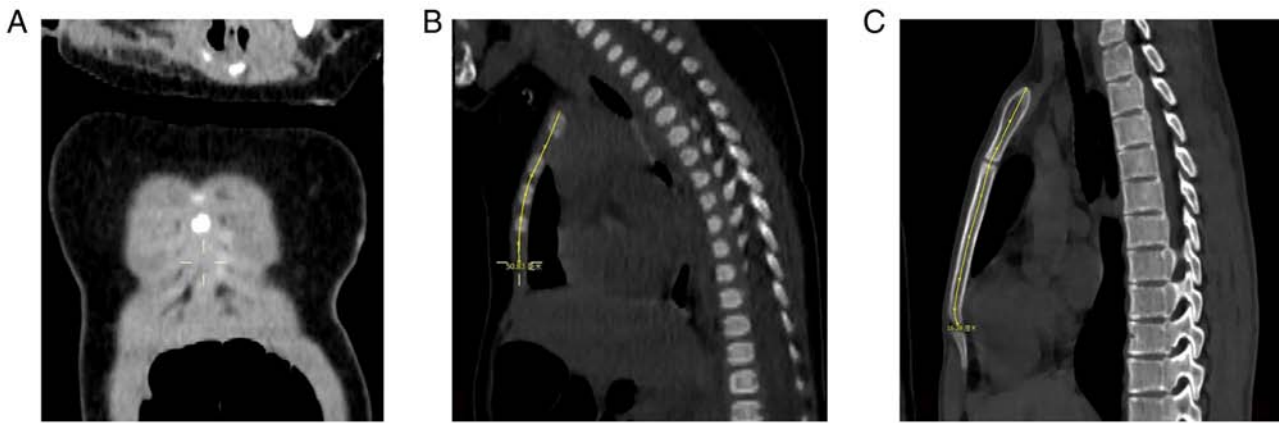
Definition of the length of the sternum. (A-C) Multiplanar reformatted MDCT images. (A) The junction of 6th/7th costal cartilage. (B) The TSDS before the ossification centers completely merged into a single ossification center. (C) the TSDS after the ossification centers have completely merged into a single ossification center, which were obtained to minimize errors caused by angulation. MDCT, multidetector-row computed tomography; TSDS, total sagittal dimension of the sternum.
